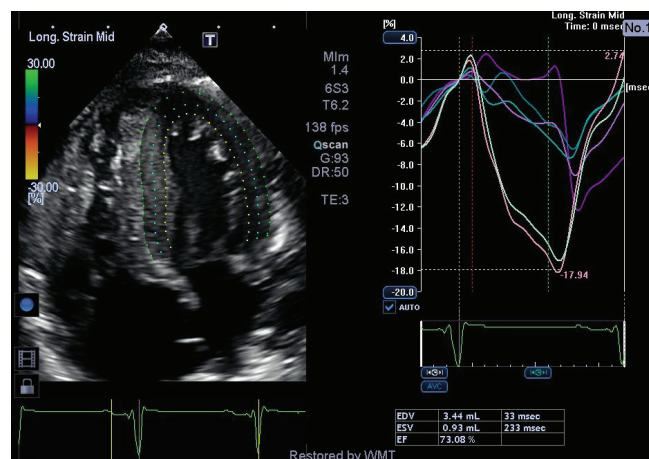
Global longitudinal strain—apical 4-chamber view.
